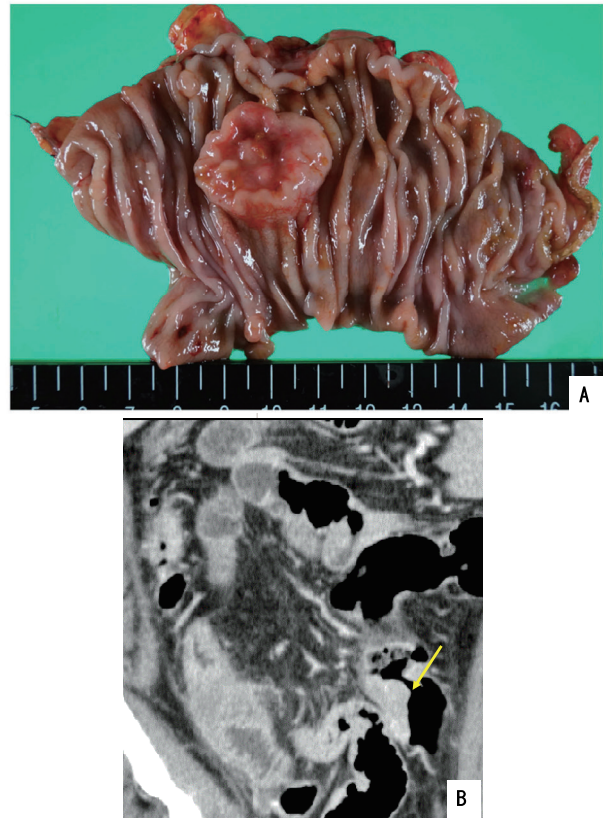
A : Type 2 sigmoid colon tumor, tubular adenocarcinoma, moderately differentiated type (tub2). Several polyps are observed in the sigmoid colon ; B : Preoperative contrast-enhanced CT showing the enhanced elevated tumor in the sigmoid colon (arrow line).
